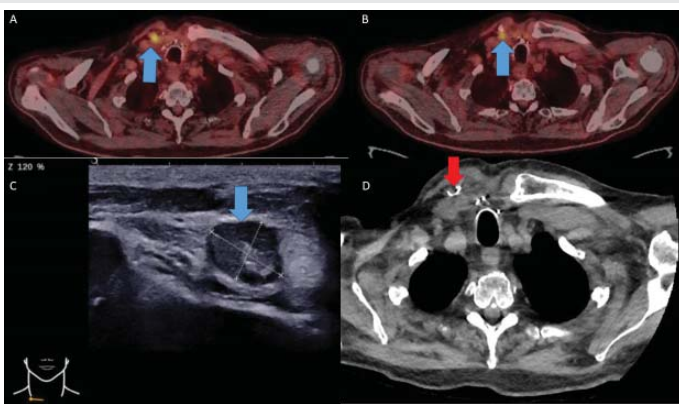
Procedure in patient No. 4. (A and B: preoperative pet scan, C: ultrasound location of the adenopathy, D: CT scan control after harpoon placement) (red arrow = harpoon, blue arrow = target).
